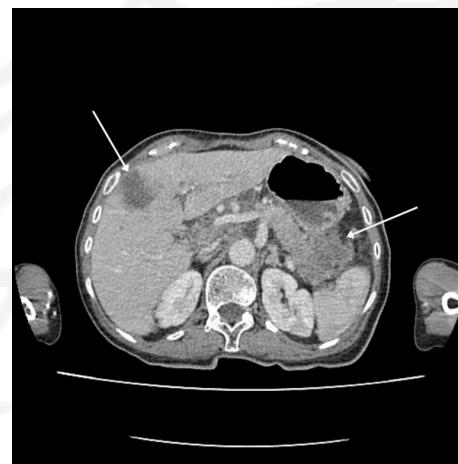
Abdominal CT image showing large expansive and infiltrative lesion in the tail of the pancreas, suggestive of primary neoplastic lesion, and heterogeneous nodular lesion in the liver, compatible with secondary implant.
